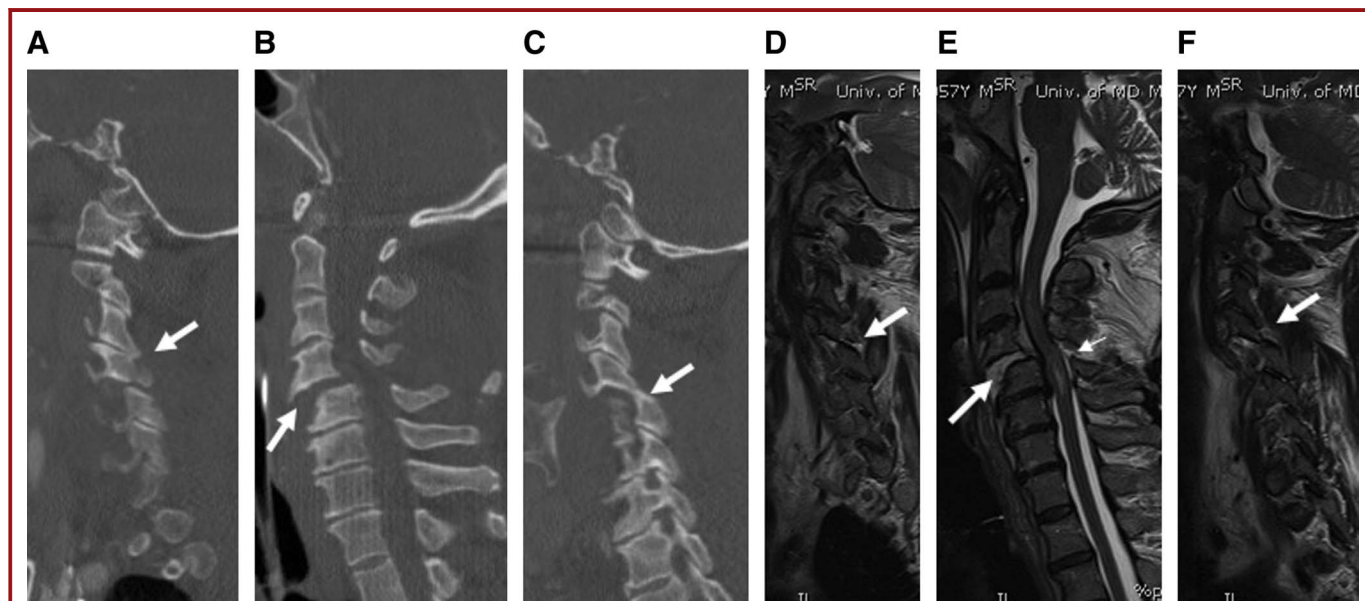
57-y-o male with motor vehicle accident 8 hours prior to admission and manifesting incomplete spinal cord injury in form of acute traumatic central cord syndrome. The SLIC severity score was 10. Sagittal reformatted views of CT and MRI depicting unilateral facet subluxation on the right side (A, D), significant translation (B, E) and perched facet on left side (C, F). Magnetic resonance imaging showed complete disruption of ALL, annulus, PLL, ligamentum flavum, interspinous and supraspinous ligaments.
